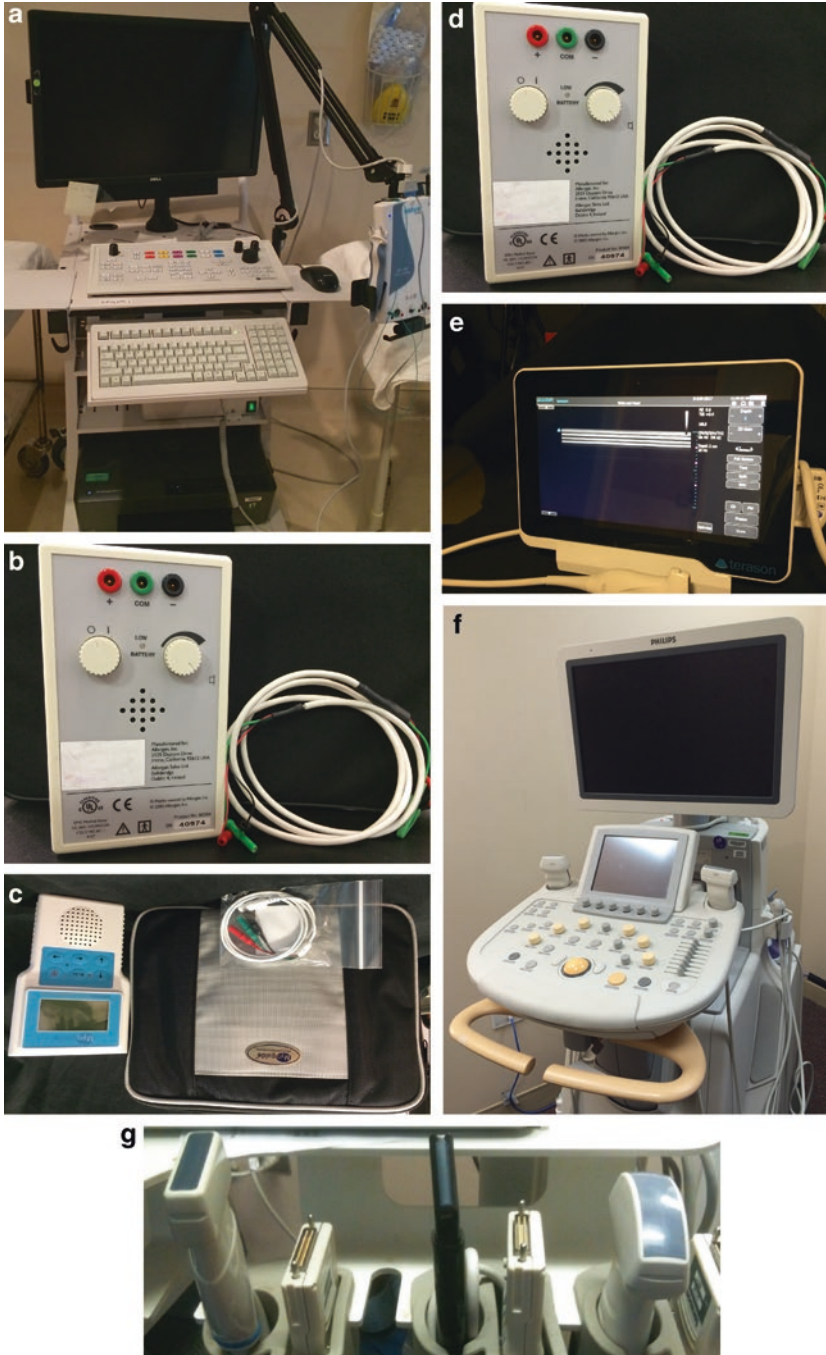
Equipment for instrumented guidance. (a) Electrodiagnostic machine, (b) EMG audio amplifier, (c) electrical stimulation unit, (d) combined electrical stimulation/EMG unit, (e) portable ultrasound machine, (f) cart-based ultrasound machine, (g) ultrasound transducers
